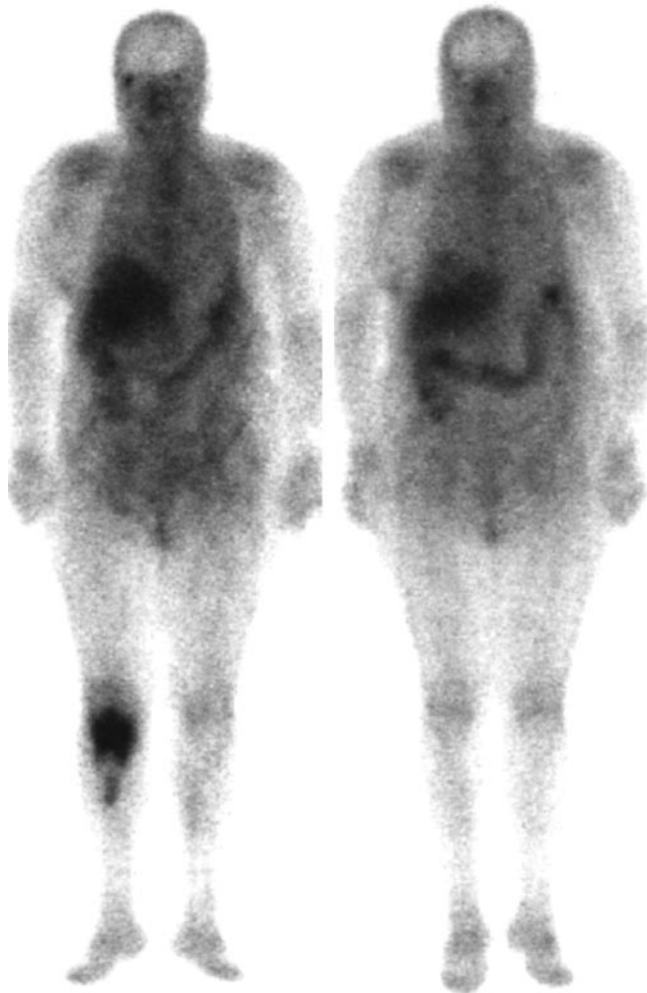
Negative ^{67}Ga scintigraphy findings during chemotherapy in 68-y-old woman with follicular mixed low-grade lymphoma involving right inguinal lymph nodes and right tibia. ^{67}Ga scintigraphy at baseline (left) shows abnormal uptake in proximal right tibia. Repeated ^{67}Ga scintigraphy after 4 cycles of chemotherapy (right) shows negative findings, which remained unchanged at end of treatment and during follow-up. Disease has been in complete remission for 12 mo.
